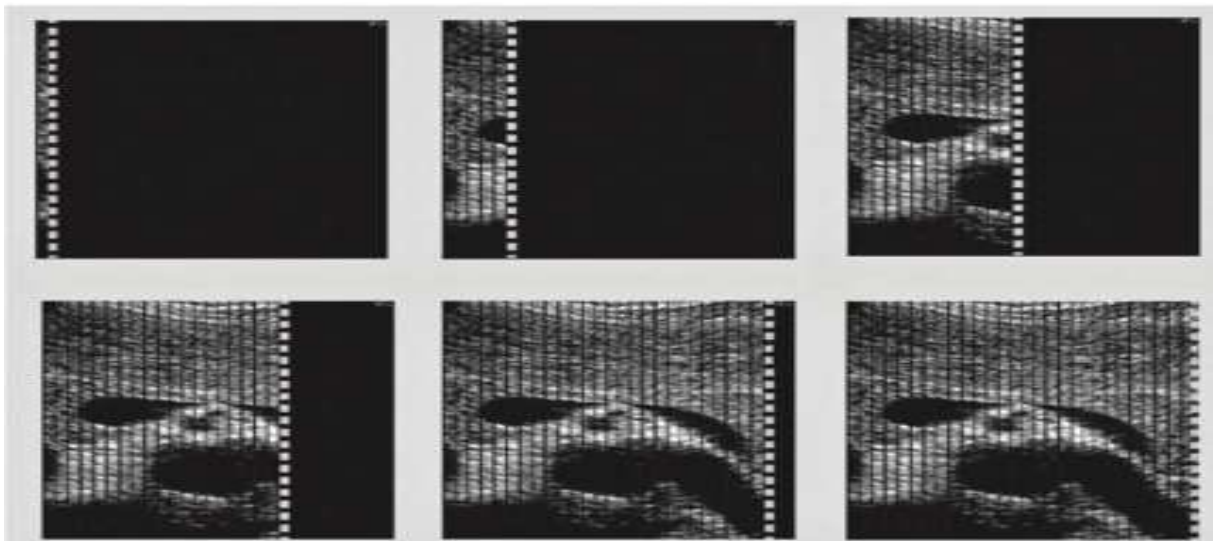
B-mode imaging A two-dimensional (2D) image is created in real time by ultrasound pulses sent along a series of successive scan lines. Each scan line adds to the image, creating a 2D representation of echoes from the object being scanned. In real-time imaging, a complete image is
